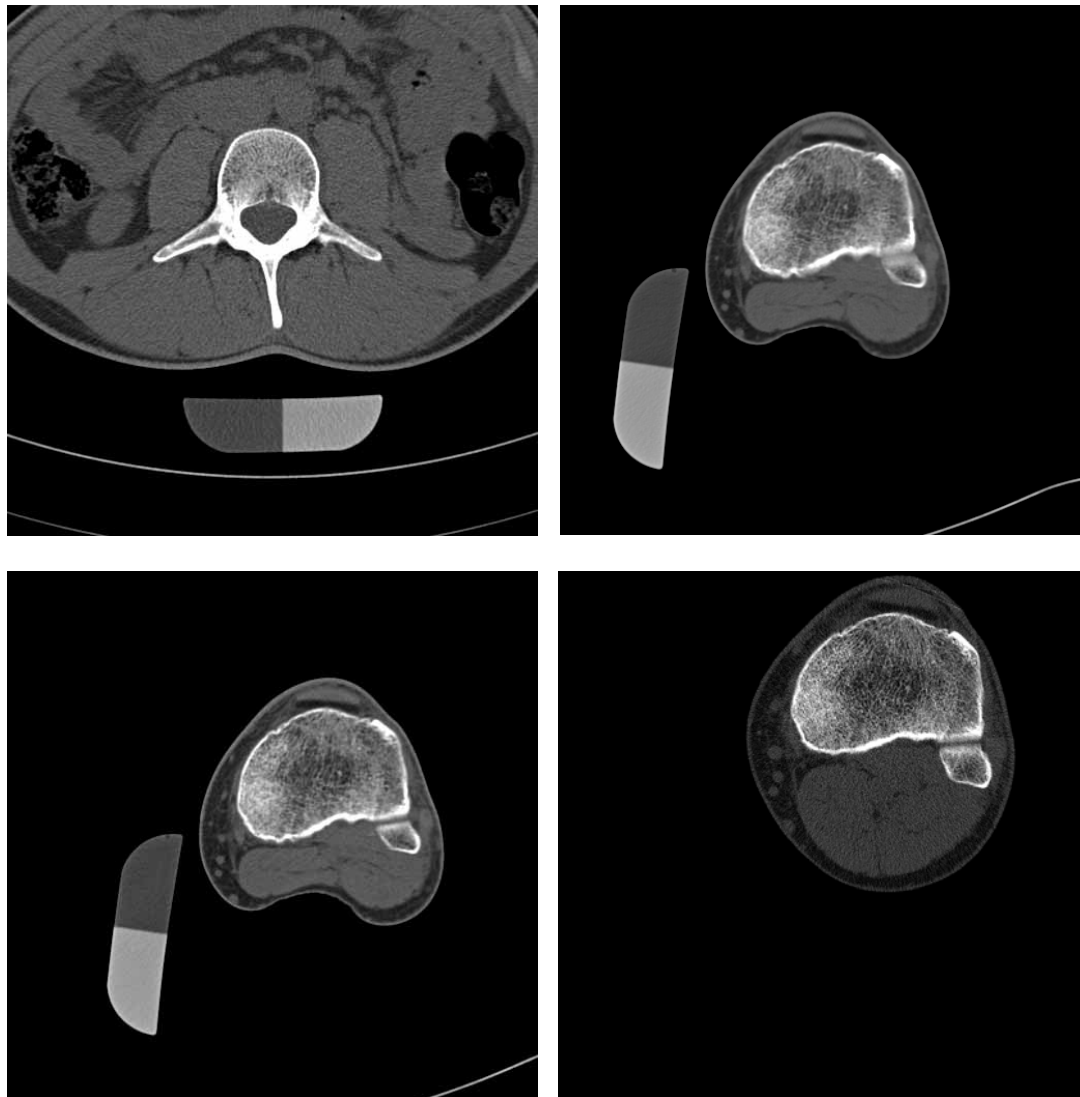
A set of CT- and pQCT-images obtained in-vivo from the same test person. *Top left:* CT-image of lumbar vertebral L3, slice thickness 4 mm. *Top right:* CT-image of proximal tibia, slice thickness 4 mm. *Bottom left:* CT-image of proximal tibia, slice thickness 2 mm. *Bottom right:* pQCT-slice through the same region of proximal tibia, slice thickness 2 mm.
